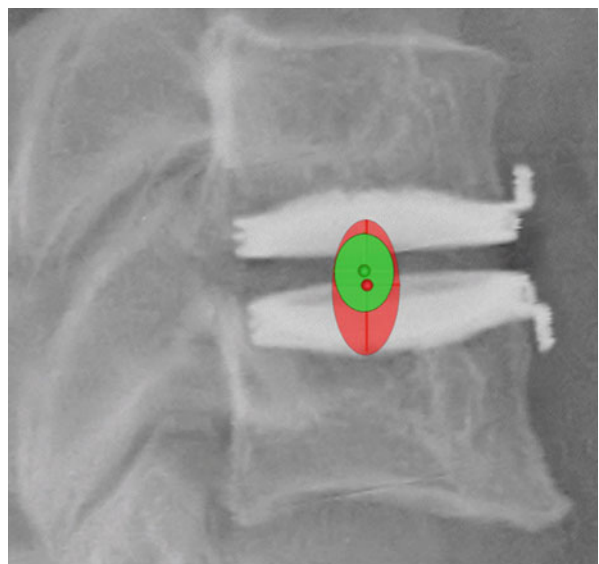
The BRYAN[®] Cervical Disc Prosthesis is demonstrated in vivo in this lateral cervical radiograph. The center of rotation (COR) has been calculated pre- and post-placement of the arthroplasty prosthesis at the adjacent surgical level. (© Courtesy of Rick Sasso, Indianapolis, IN)
